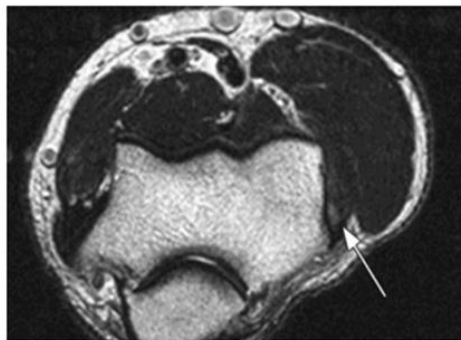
Mild lateral epicondylitis. Axial T2-weighted fast SE MR image obtained in a 44-year-old man demonstrates a focal region of intermediate signal intensity within the common extensor tendon origin (arrow).
